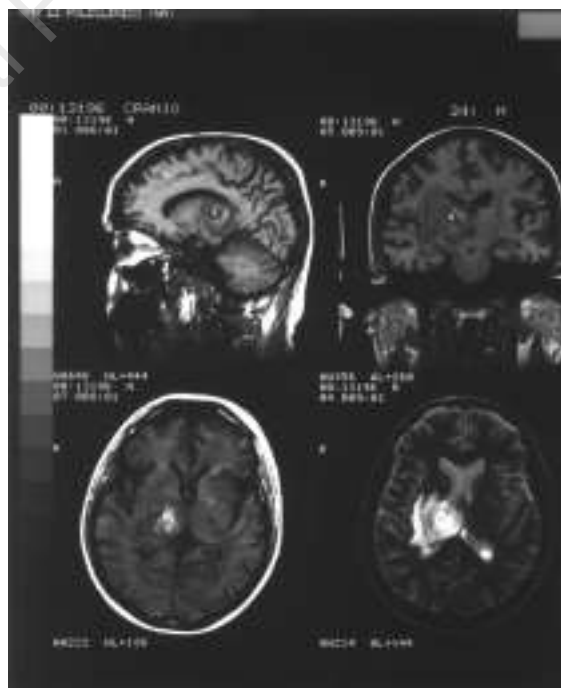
Cerebral MRI. Gradient recalled echo (GRE) sagittal and coronal T1-dependent pre-contrast images (top) demonstrate a round lesion in the right thalamus, with several concentric components (central: high intensity; intermediate: low intensity; peripheral: high intensity) surrounded by a low intensity edema. In the edematous region a post-contrast (Gadolinium-DTPA) GRE image (bottom, left) shows the presence of a thin ring-shaped enhancement. In the spin-echo (SE) T2-dependent image (bottom, right) the center of the lesion appears hypointense.
